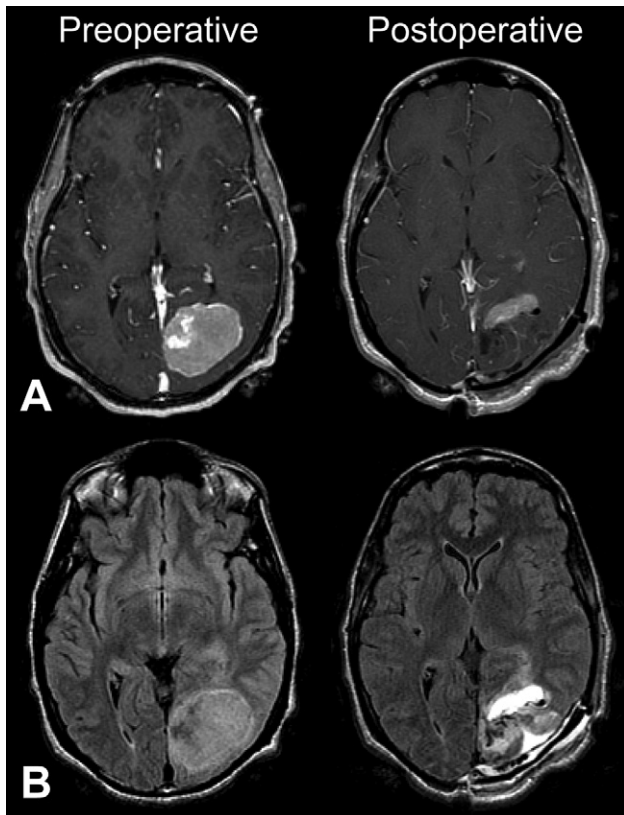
(Left) Preoperative axial MRI showing a $4.75 \times 4.0 \times 3.7$ cm left occipital extra-axial mass associated with the tentorium. (Right) Postoperative imaging 3 days after the operation was consistent with left occipital craniotomy with gross total resection of the enhancing portion of the tumor. (A) T1-weighted contrast enhanced MRI, (B) fluid attenuated inversion recovery MRI.
